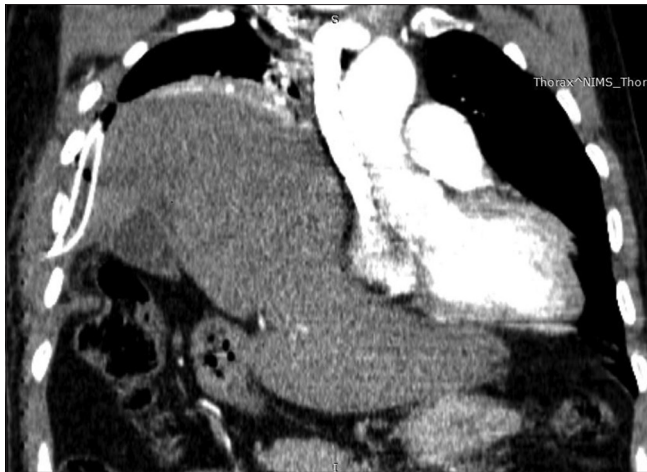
Coronal transformation of CT thorax, showing anterior part of ruptured leaf of the diaphragm with ICTD *in situ*, right lobe of liver, omentum, gall bladder, a segment of hepatic flexure herniating into the thoracic cavity through the vent in the diaphragm with capsular breach of the posterior part of the right lobe of liver, and collapsed lower lobe of the right lung
